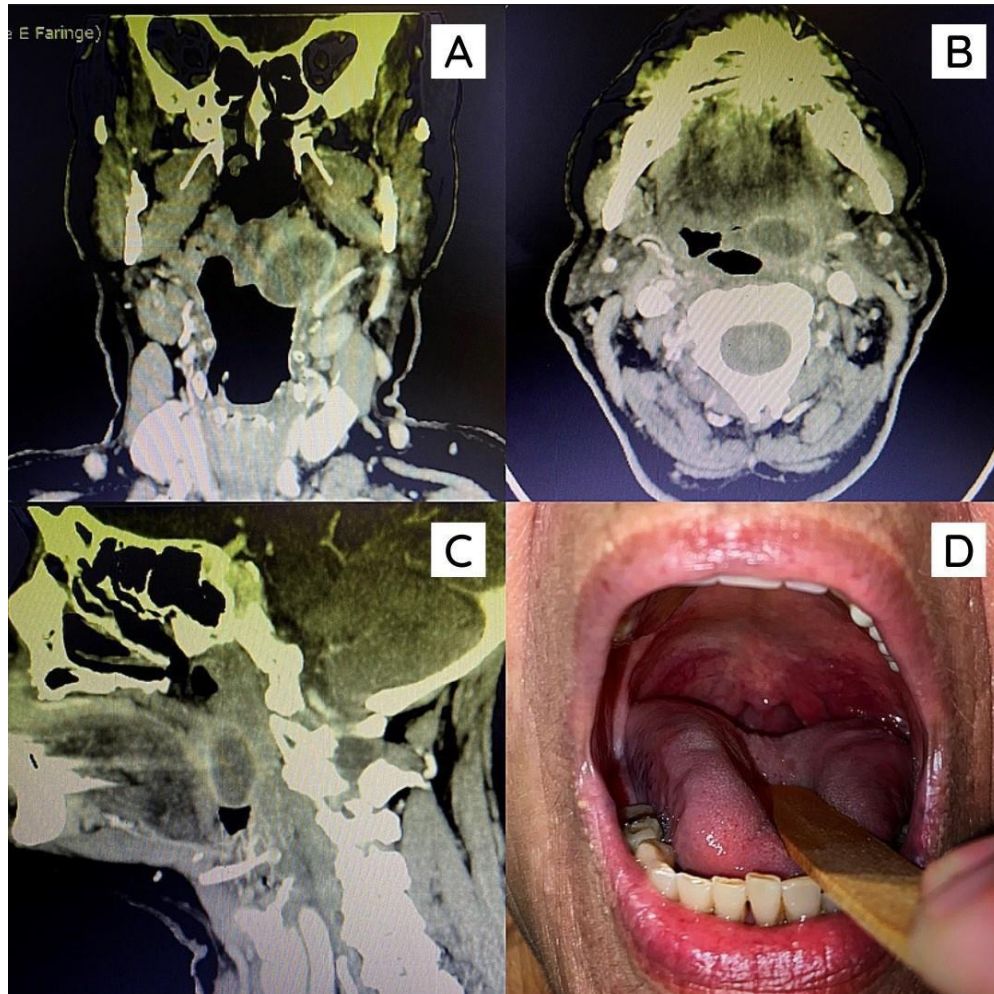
Computed tomography of the neck showing collection in space parapharyngeal (A: coronal section, B: axial section, C: sagittal section). D: oroscopy after spontaneous abscess drainage
